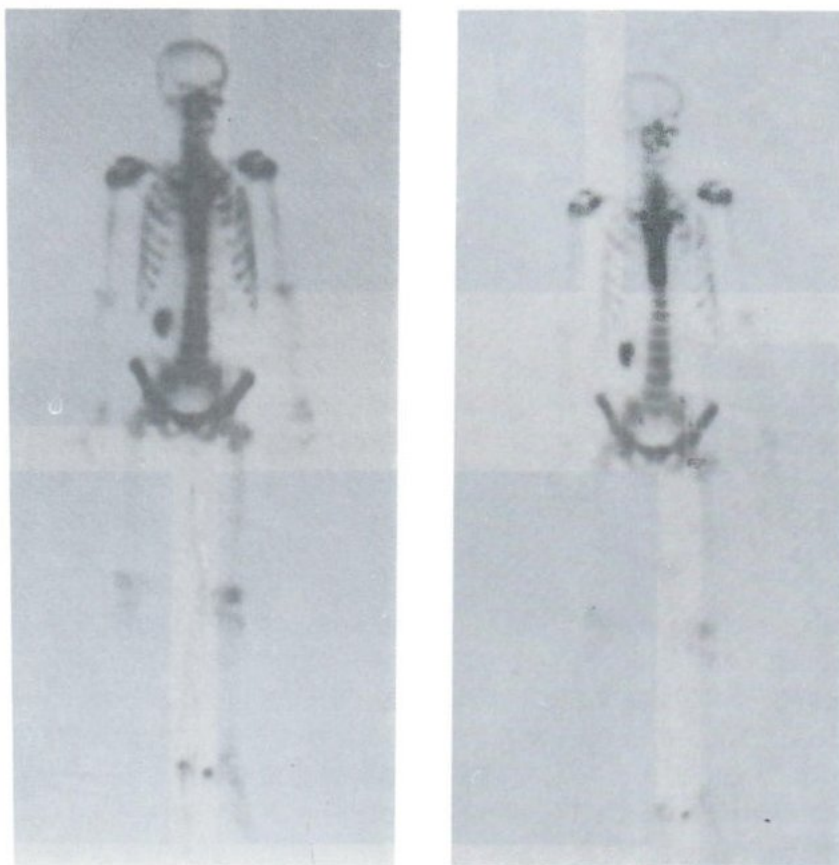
Bone scintigraphy revealed increased uptake at multiple sites.
